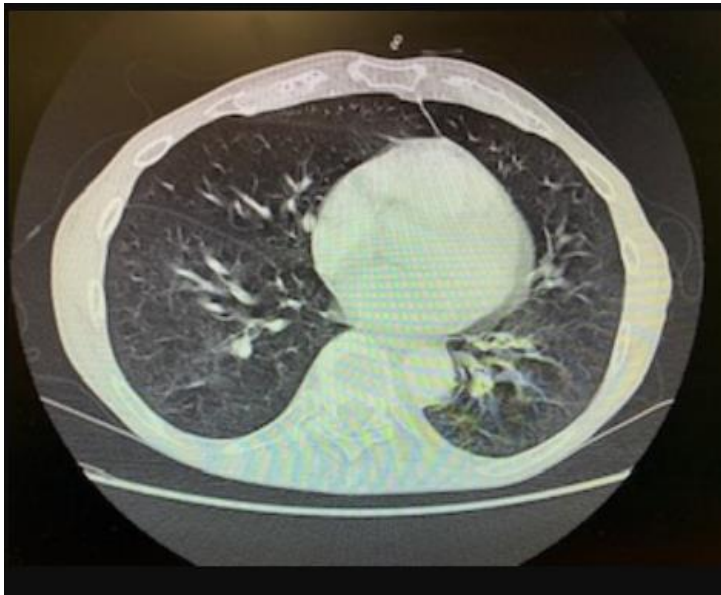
Computerised tomography (CT) scan of Chest on 3rd admission confirming no active features suggestive of COVID-19
